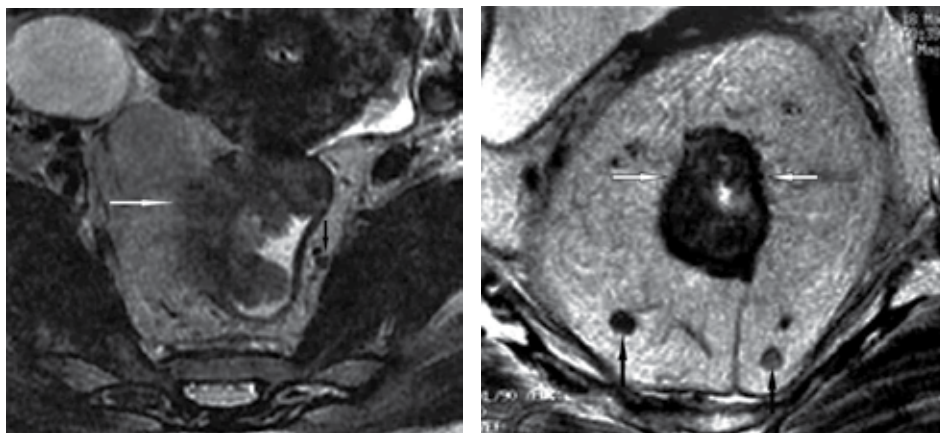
MRI – a view of T-3 carcinoma - 3-D reconstruction after real-time software rendering.
